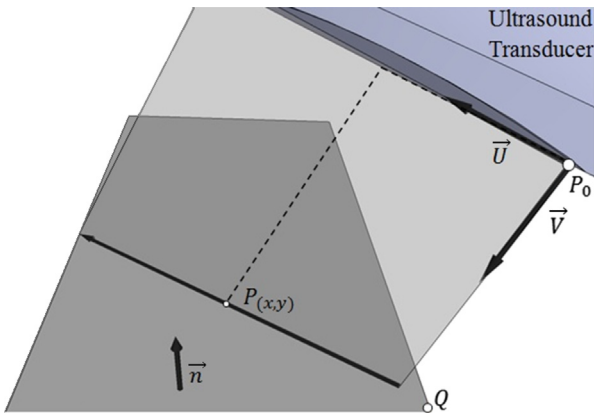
Intersection of the ultrasound image and the wall plane. \vec{U} is a unit vector in the direction passing through the center of array elements (lateral), and \vec{V} is a unit vector in the direction of the ultrasound beam (axial). P_0 is the origin of the imaging plane. The plane equation is defined with the normal vector, \vec{n} , and a point, Q .
